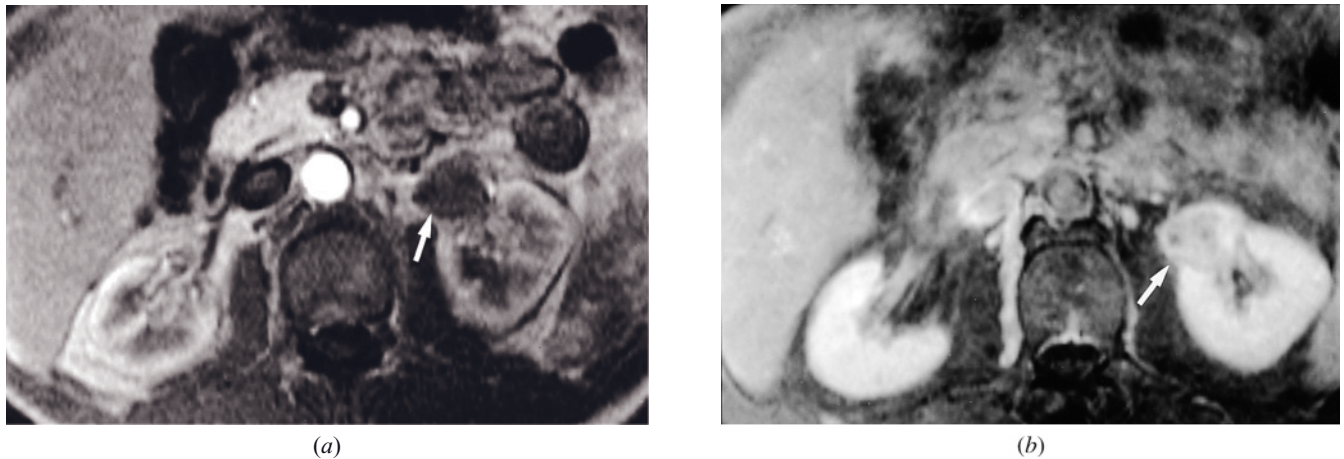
Lymphoma, solitary mass. T1-weighted immediate postgadolinium SGE (a) and 90-s fat-suppressed gadolinium-enhanced SE (b) images. A solitary lymphoma mass is present in the left kidney (arrows, a, b) that is minimally enhanced on the capillary-phase image (a) and heterogeneous and moderately enhanced on the interstitial-phase image (b). (Reproduced with permission from Semelka RC, Kelekis NL, Burdeny DA, Mitchell DG, Brown JJ, Siegelman ES: Renal lymphoma: demonstration by MR imaging. *AJR Am J Roentgenol* 166: 823-827, 1996.)
